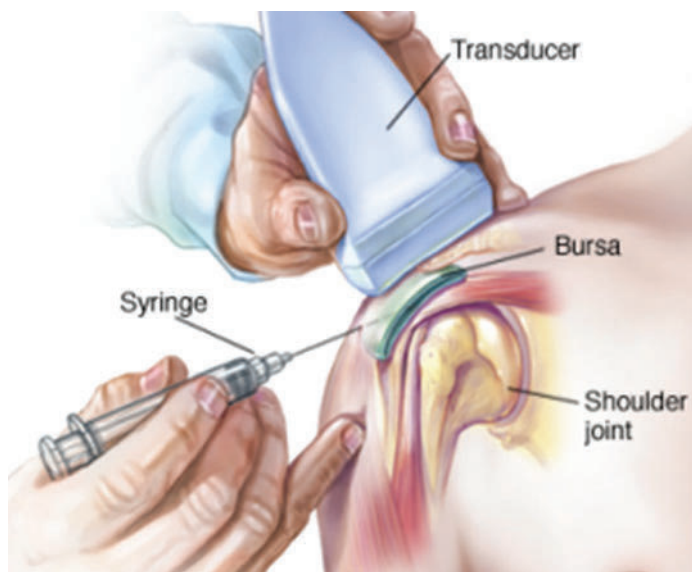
Depiction of ultrasound-guided needle injection to reduce harmful radiation exposure. *Image courtesy of the Mayo Clinic.*
